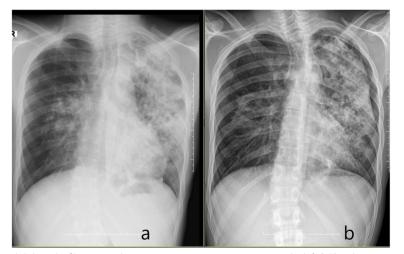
a The chest X-ray reveals bilateral infiltration and cavitary appearance, more intense on the left. b The chest X-ray reveals a pneumothorax on the left compared to the previous radiograph
